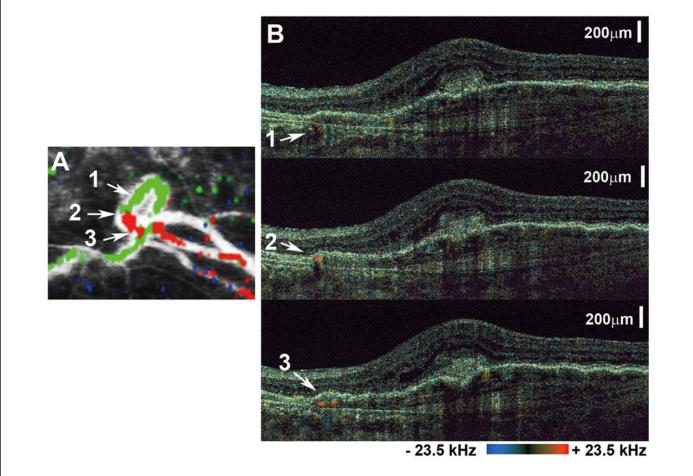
Doppler OCT images of the feeder vessel. In the high-magnification Doppler OCT angiography image of the feeder vessel (A), the distribution of Doppler signals from the retina, choroid, and the space between the RPE and Bruch's membrane are color-coded blue, green, and red, respectively. The transition point from green to red represents the penetration site of the feeder vessels through Bruch's membrane. A series of colored Doppler OCT images (B) show penetration of the feeder vessels across Bruch's membrane, and arrows indicate the position of Doppler signals in the colored Doppler OCT images.
